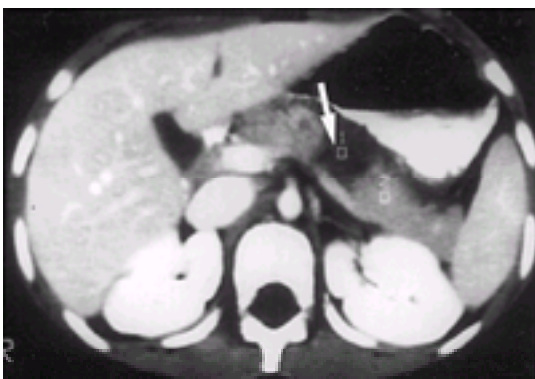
Abdominal computed tomography from a 6-year-old boy who fell onto the handlebar of his bicycle, showing a pancreatic hematoma and pseudocyst formation.
